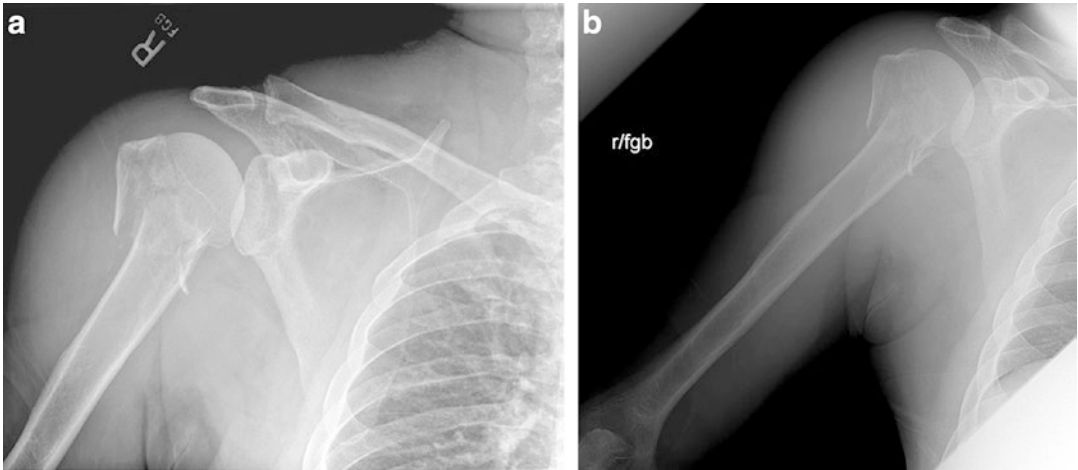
AP radiographs of the right shoulder (a) and humerus (b)
